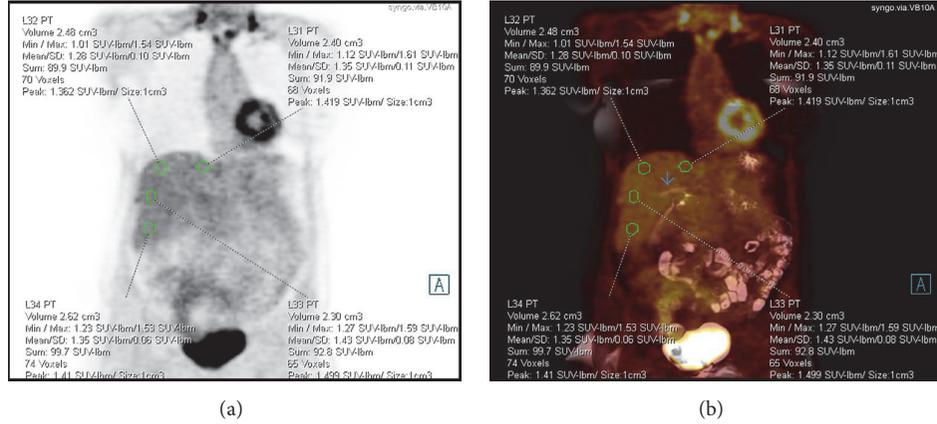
(a) Coronal PET attenuation correction image with spheres located inferior to, superior to, and at the level of the portal vein as well as in the left lobe of the liver. (b) Coronal fused T2-weighted HASTE FS PET/MR image demonstrating the spheres related to the portal vein (arrow).
